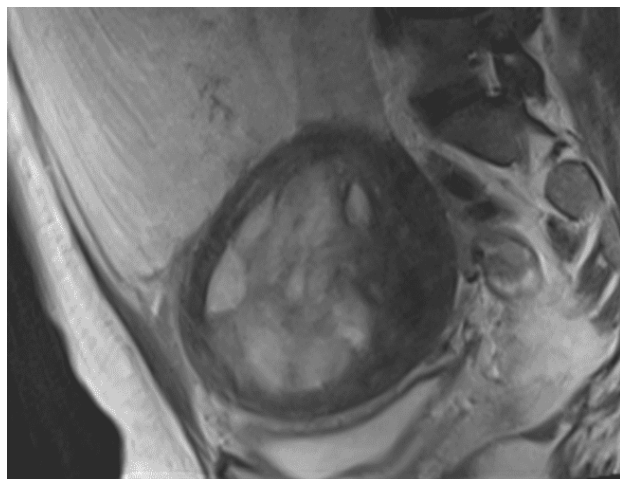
Coronal T2-weighted image demonstrating the enlarged uterus with multiple leiomyomas and separate visualization of the right ovary
